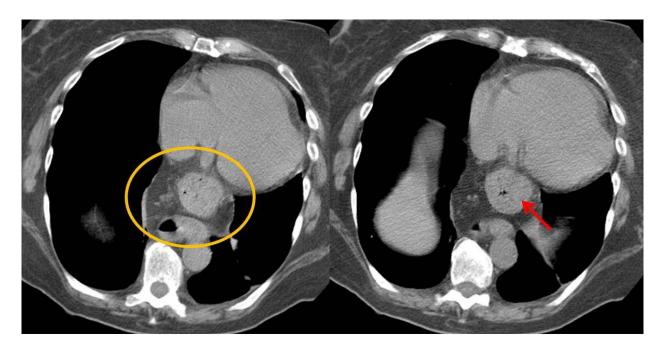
Hiatal hernia. CT scan of the abdomen shows widening of the esophageal hiatus, with cephalic herniation of the stomach (arrow).
